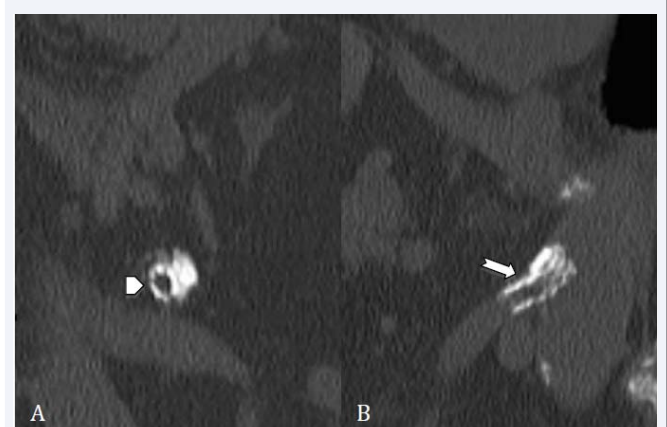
Case 1. Postoperative CTA showing patent stent in the SMA with no relevant stenosis and dense eccentric calcification. A: coronal plane (arrow head). B: sagittal plane (arrow).
